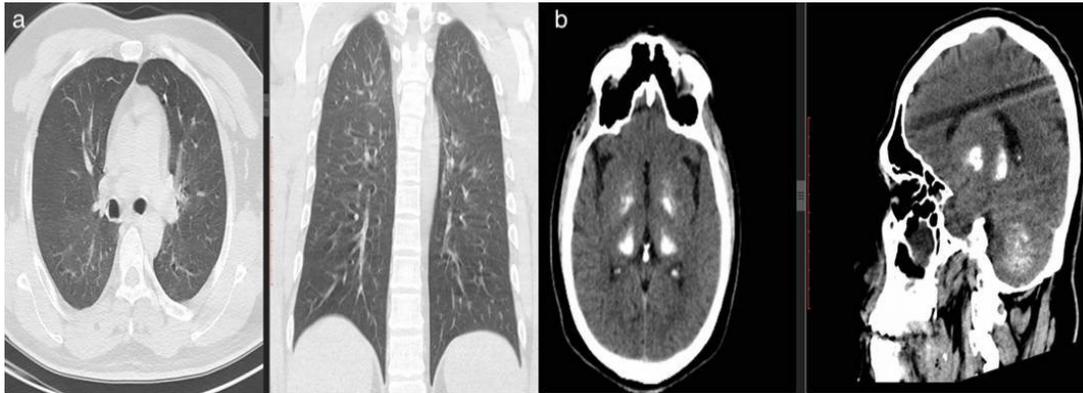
a Thoracic computed tomography at first admission was normal, b Non-contrast brain CT shows bilateral basal ganglia and dentate nucleus symmetrical calcifications
